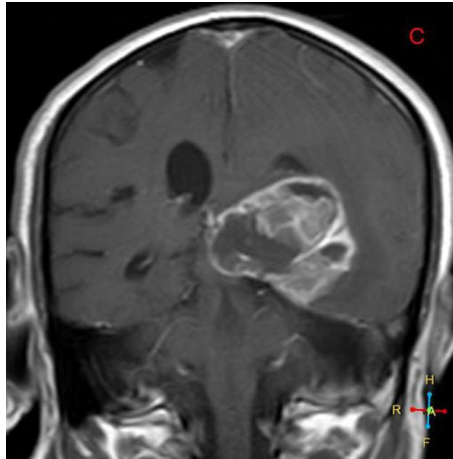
Brain MRI showing the presence of a Glioblastoma ¹⁴
